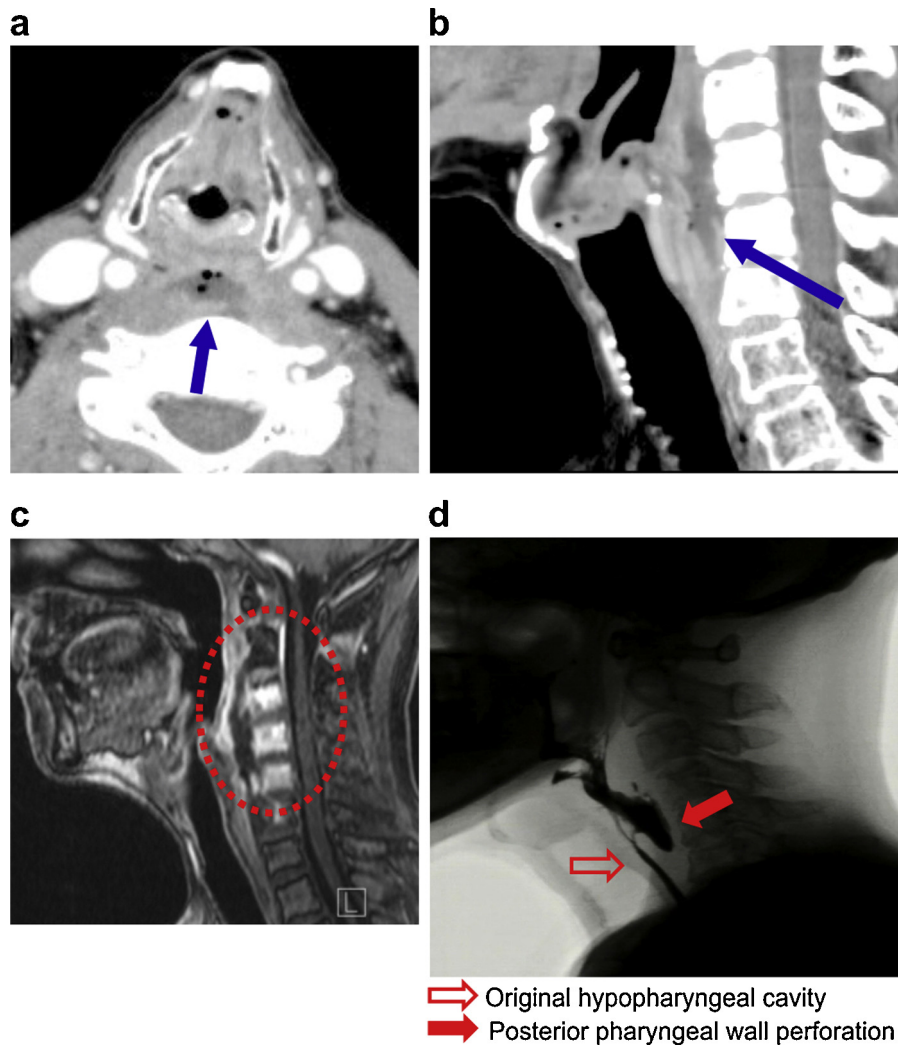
((a) and (b)) Computed tomography, (c) magnetic resonance imaging, and (d) transillumination findings.
